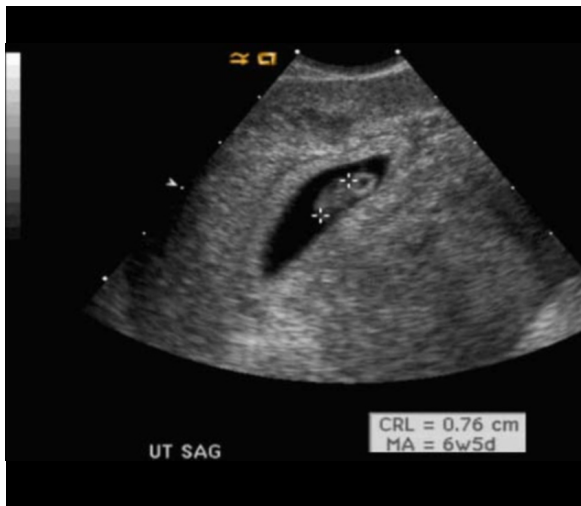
Follow up to surgical excision of the right tubal pregnancy. Transvaginal ultrasound showed interval growth of the intrauterine gestation, now measuring 7.6 mm and corresponding to a 6 week 5 day gestation.
